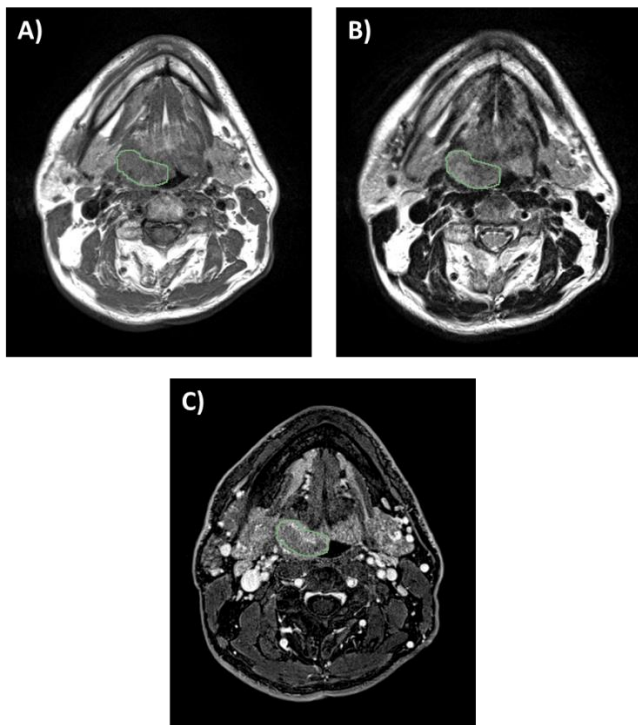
Example of images used for the study: T1-weighted image (A); T2-weighted image (B); T1-weighted fat sat image (C).
